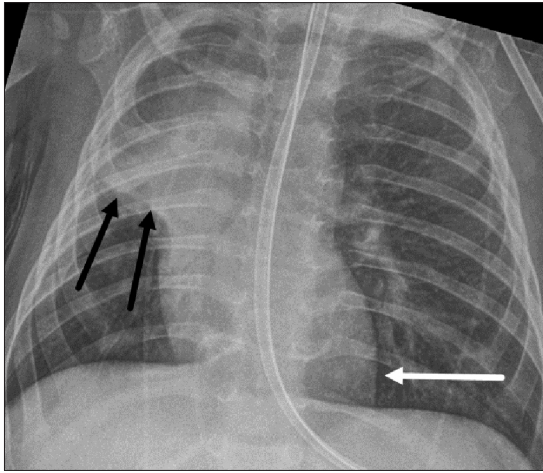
Chest radiograph of a 5-month-old male infant with adenovirus infection shows right upper lobe collapse (black arrows) and resultant rightward mediastinal shift (white arrow)
